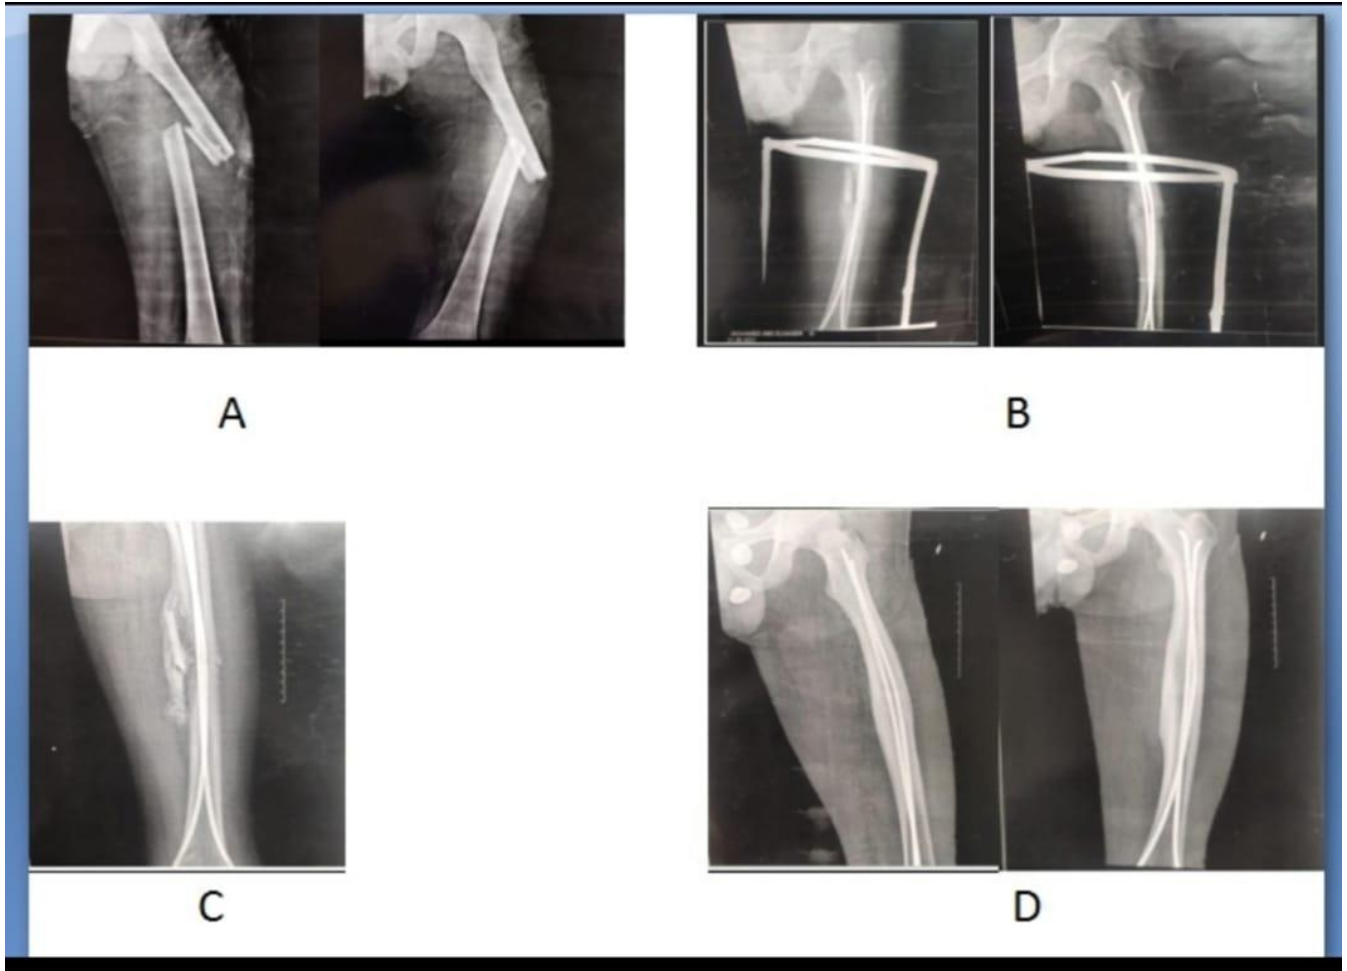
Patient profile: Female child, 14 Years old, with fracture of left side femur. A) Antero-posterior and lateral X-rays of the right femur showed oblique midshaft fracture with wedge fragment. B) 8-week postoperative X-ray AP and Lateral views showed fracture callus consolidation, C) 3 months postoperative X-ray AP views showing incomplete fracture healing. D) one-year follow-up showed complete union and remodeling of bone
